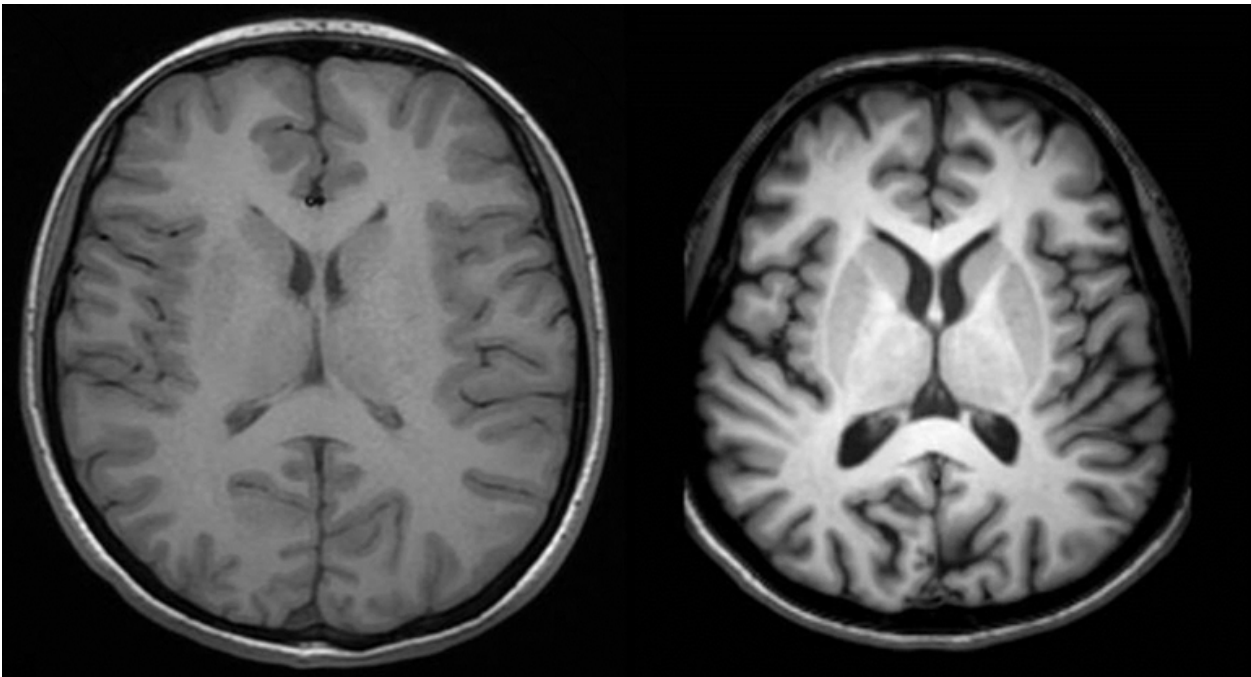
T1-weighted axial MRIs acquired with 1.5 T (left) and 3T (right) MRI scanners. 3T MRI was acquired with a field of view of 25 cm and 256 x 256 matrix, 1-mm slice thickness. Image was acquired using a turbo field echo sequence, gated to achieve an effective TR of >8 ms and TE of 4 ms. 1.5T MRI was acquired with field of view of 24 cm, 1.5 mm slice thickness. Image was acquired using a spoiled gradient recalled acquisition sequence, gated to achieve an effective TR of >35 ms and TE of 15 ms
